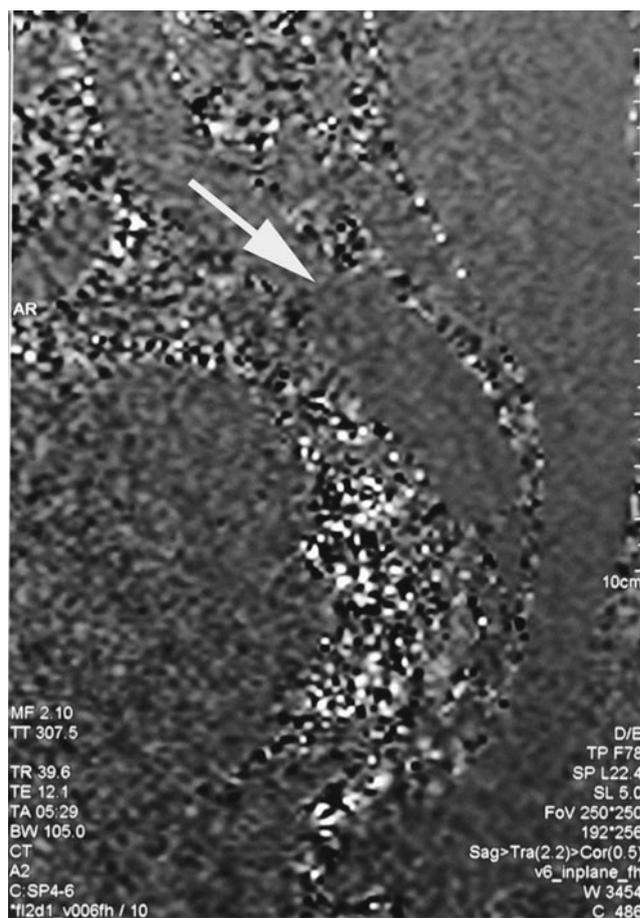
Preoperative sagittal plane-MRI revealed spinal cord tethering and low lying conus medullaris accompanying with a large, centrally located intrasacral meningocele between S2 and S4 segments
